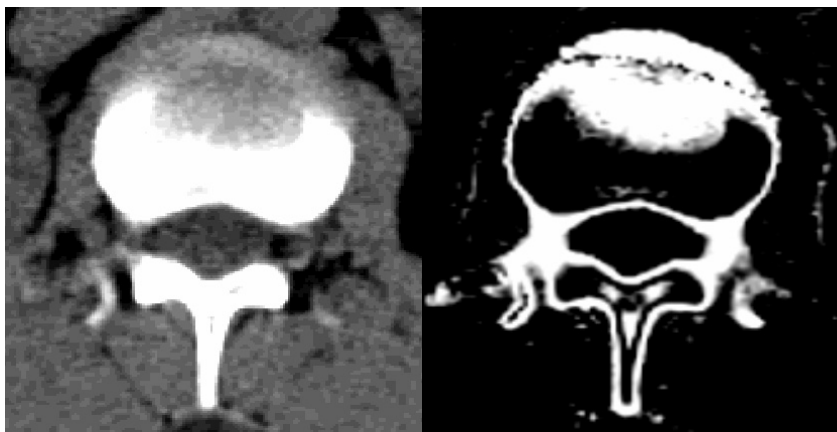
Original CT slice (left) and contour extraction (right)
